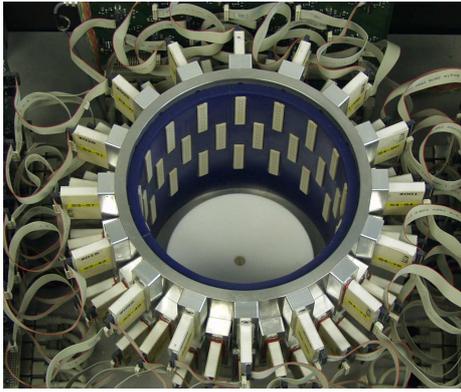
Ultrasound breast cancer scanner developed by Forschungszentrum Karlsruhe (courtesy of Forschungszentrum Karlsruhe).
